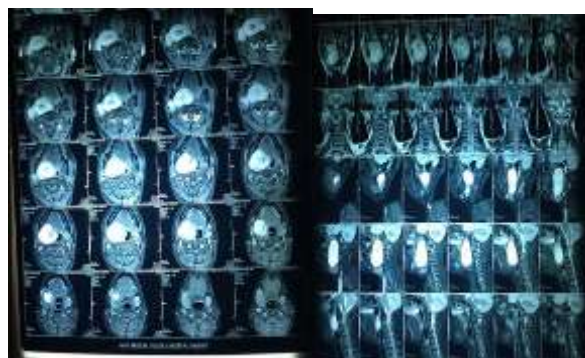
MRI axial and coronal cuts showing parapharyngeal mass displacing internal jugular vein and carotid artery posteriorly.
